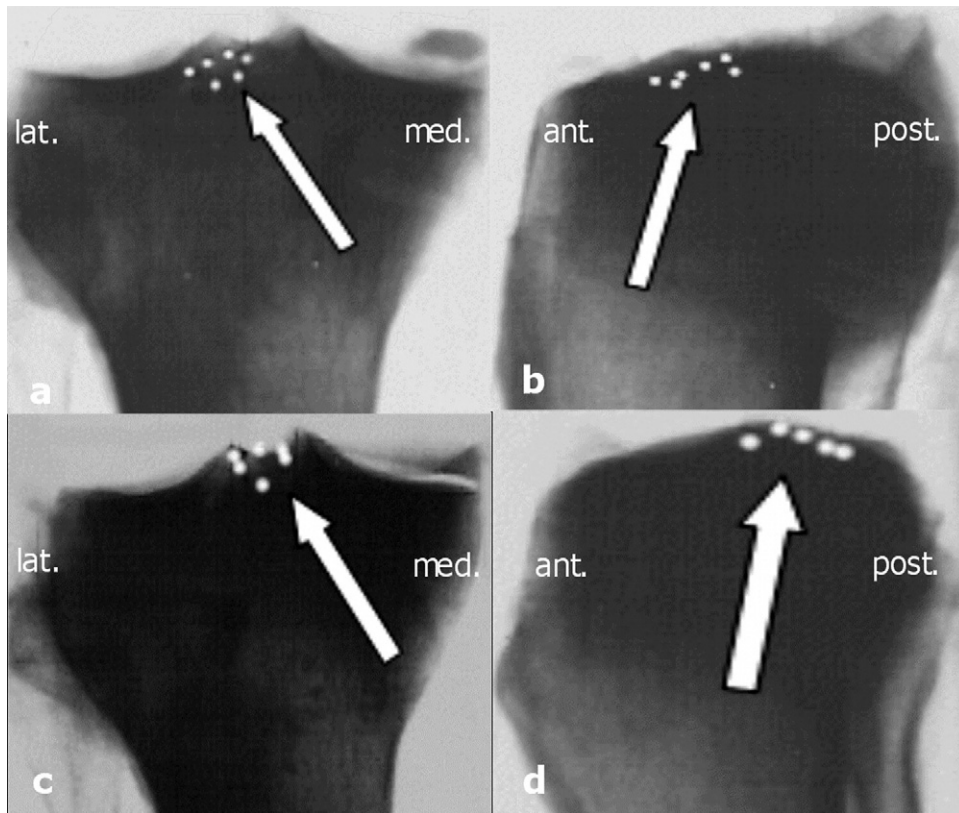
Standardized AP and lateral radiographs of tibia heads with prepared (a, b) anterior and (c, d) posterior horn sites; white marks indicate radiopaque steel balls (arrows). (post, posterior; med, medial; lat, lateral; ant, anterior.)
